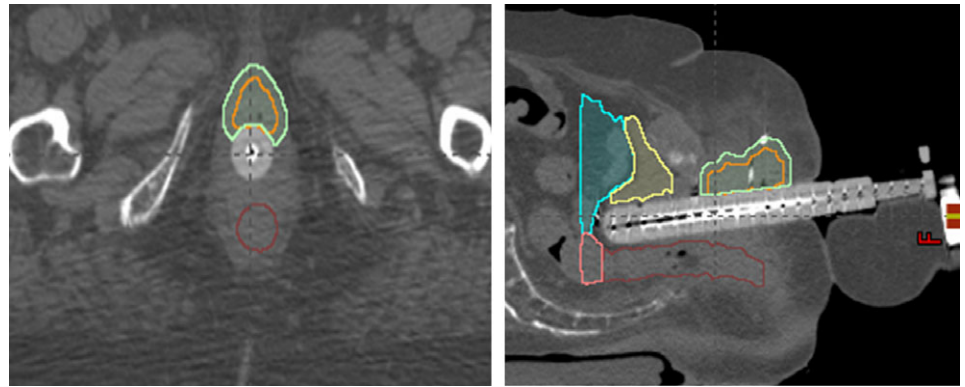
Separation of organs at risk such as rectum from the gross tumour volume (orange) and PTV (green) using the vaginal cylinder as shown on an axial and sagittal views of the CT images.
